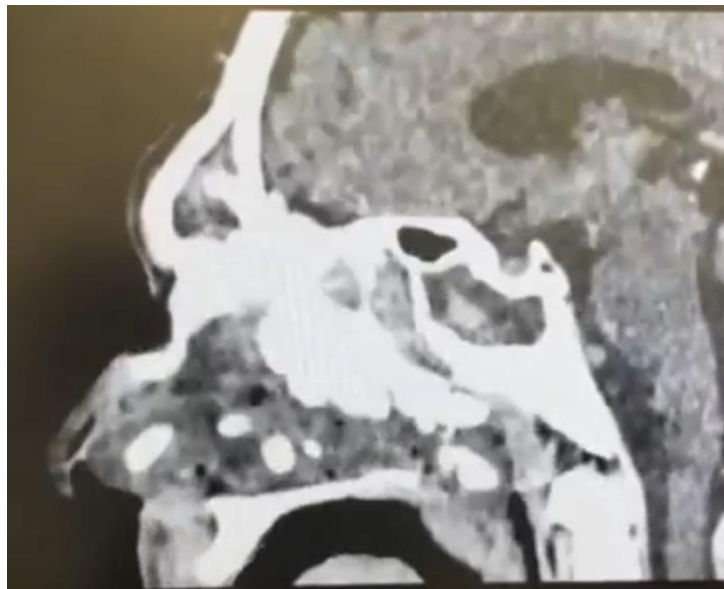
CT (sagittal section) of a patient with CRS, with rhinoliths due to work in an occupationally hazardous environment.
